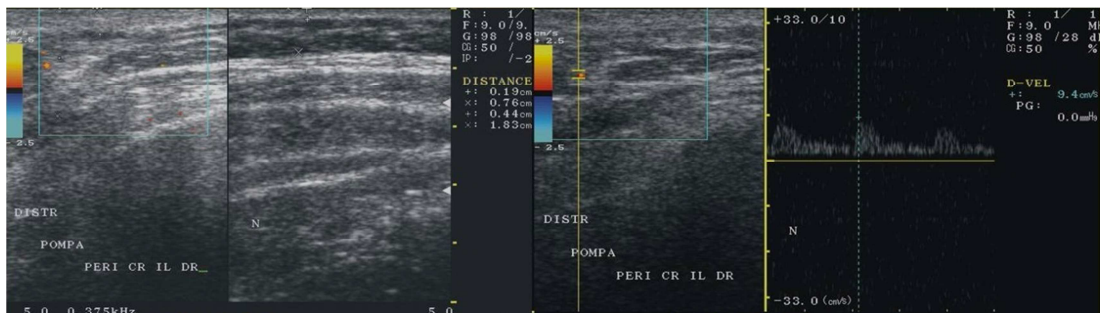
A Lower-Lateral Abdominal Area Repeatedly Infused by Pump. A Complex Multilayer Dystrophy with No Clear Delimitation between Cutis, SC and Muscularis, Initially (Left) vs Normal Nearby Aspect (Right on the Split Screen Image). After 6 Months there is No Remission; Color/pw Arterial Doppler Signal Can Be Seen (Right).
